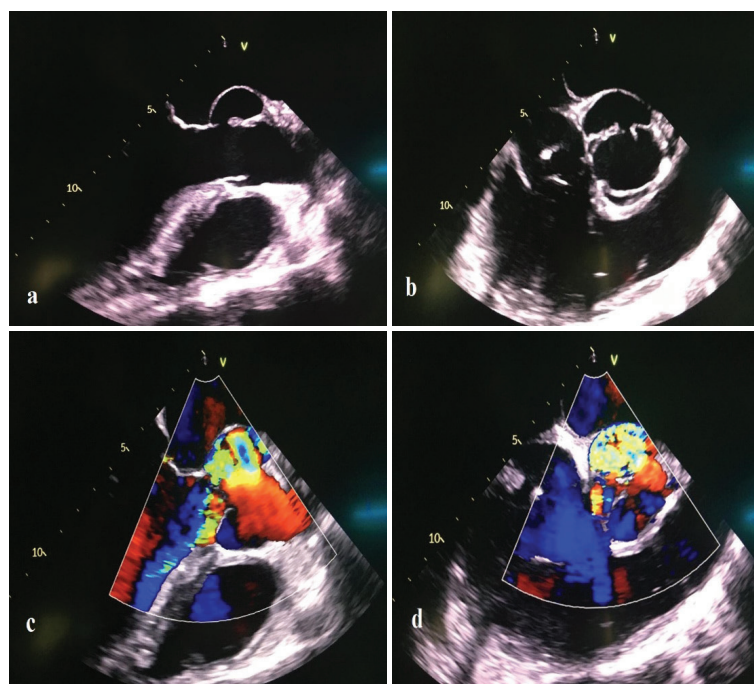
Intraoperative transoesophageal echocardiography showing: A, B) pseudoaneurysm cavity communicates with left ventricular outflow tract; C) massive aortic regurgitation; D) turbulent flow within the whole pseudoaneurysm cavity.
